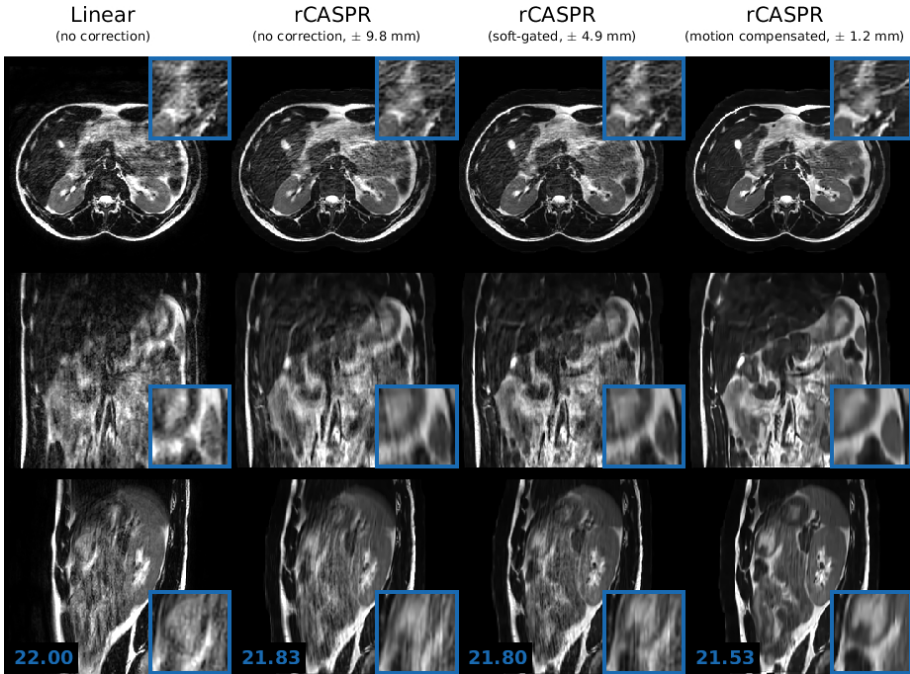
Volunteer 1: Comparison of image quality in T_2 -w free-breathing 3D turbo spin echo scans for linear, rCASPR, soft-gated rCASPR and motion compensated rCASPR. For all the reconstructions the residual peak-to-peak motion was estimated using the 4D-MRI. For rCASPR the residual motion was ± 9.8 mm, soft-gating rejected 50% of the data such that the residual motion was ± 4.9 mm and motion compensation had residual intrabrain motion of ± 1.2 mm. The numbers in left bottom corner indicate the global gradient entropy. Blue boxes present zoomed regions. *Acronyms: rCASPR = rewound cartesian acquisition with spiral profile ordering.*
